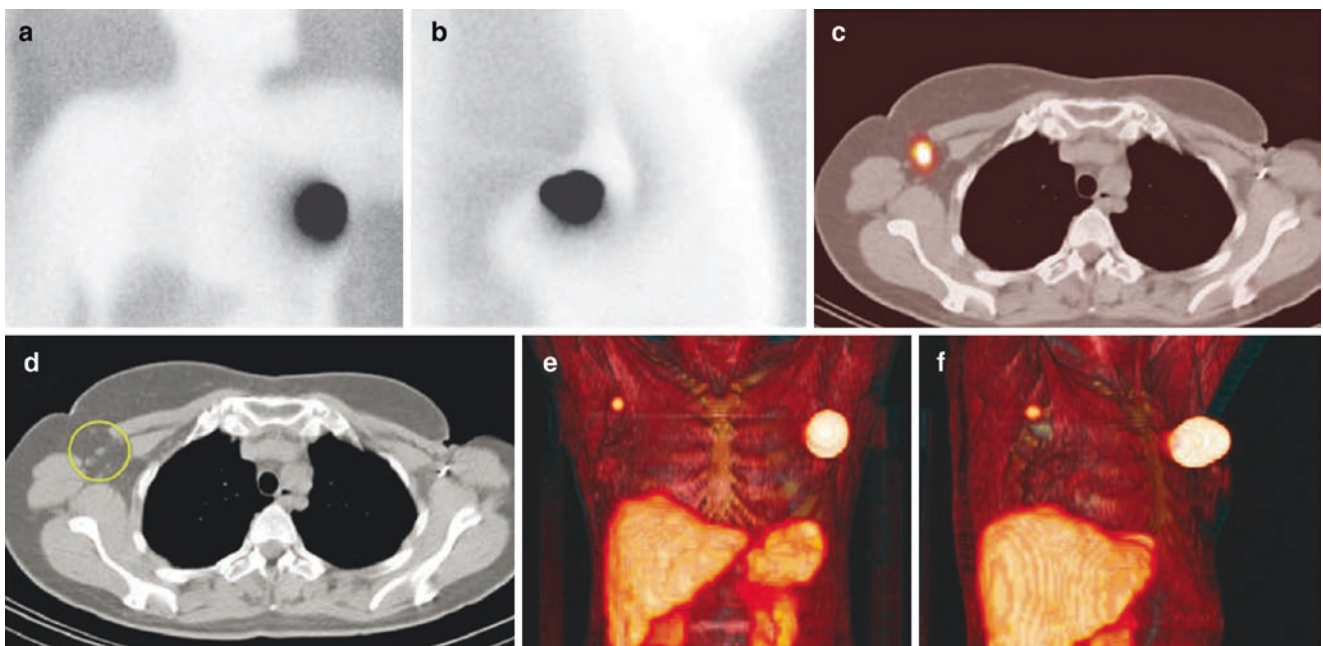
Example of lymphatic drainage to the contralateral axilla in a patient with breast cancer. Anterior (a) and left lateral (b) planar images showing no drainage from the site of intratumoral radiocolloid injection in the left breast (body contour obtained with a flood source placed beneath the patient's body). By contrast, on the fused axial SPECT/CT
